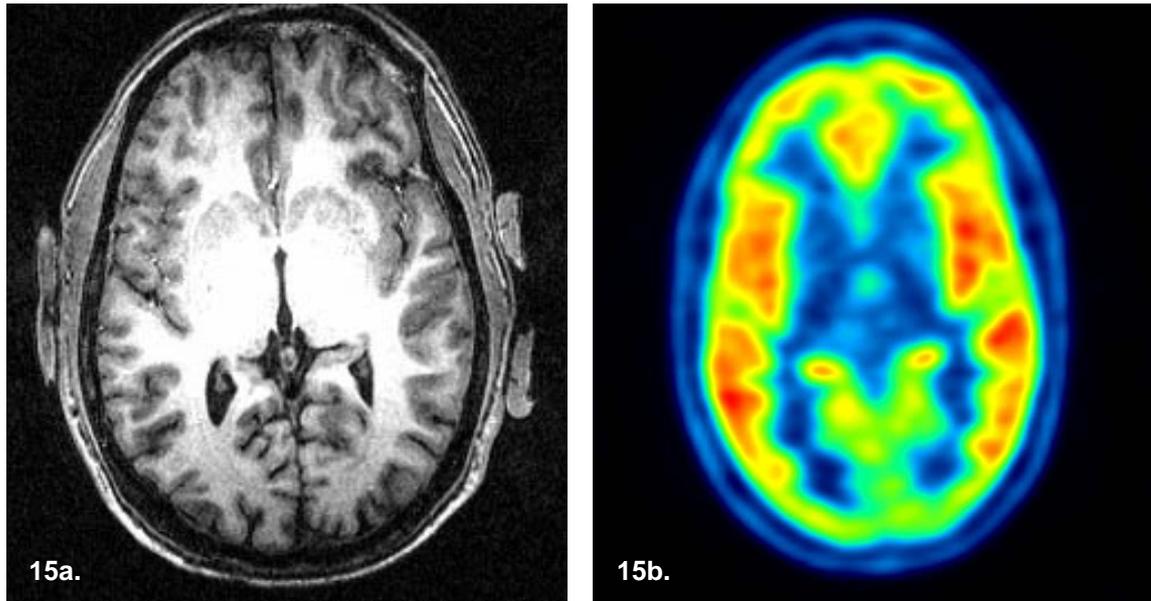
Individual T1-weighted MR image
